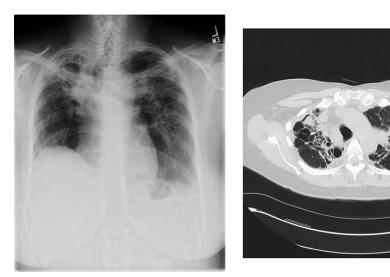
Chest x-ray and CT of sarcoidosis patient with pulmonary fibrosis and SAPH.
